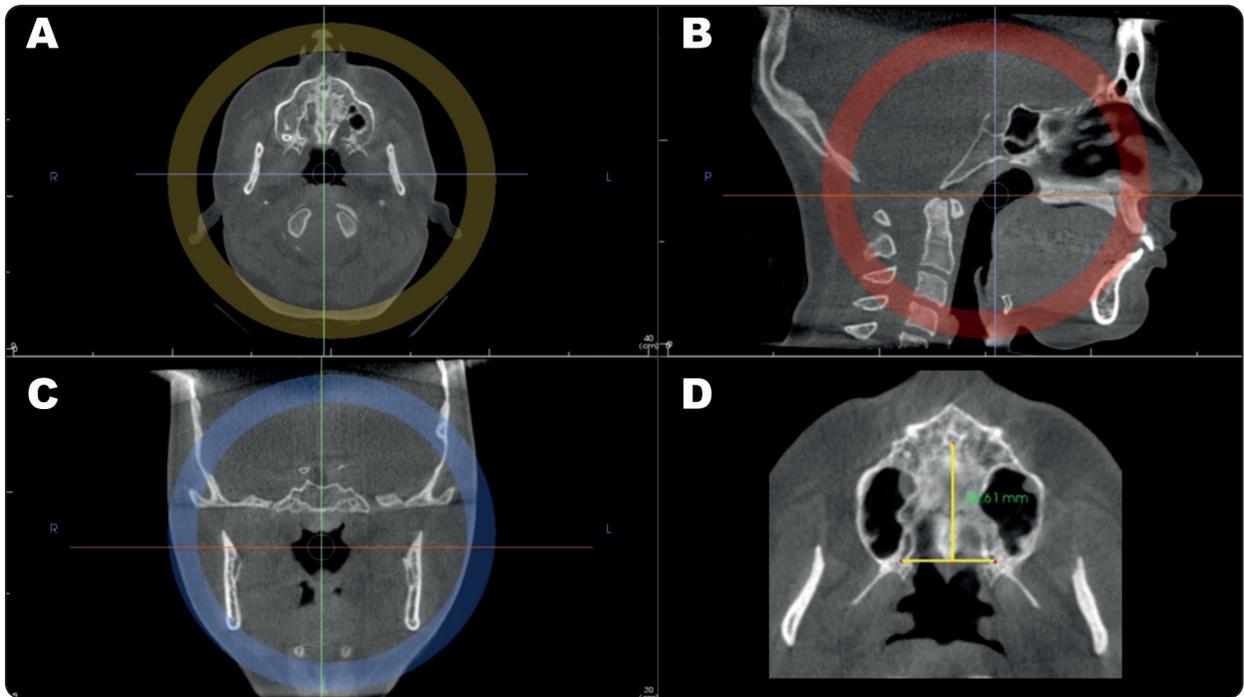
CBCT images revealing MPS length measurement: (A, B, C) Orientation lines on the (A) axial, (B) sagittal, and (C) coronal planes, (D) MPS length was measured on the axial plane as the distance from the posterior margin of the incisive foramen to the intersecting point with a line tangent to the posterior margins of the two greater palatine foramina.
